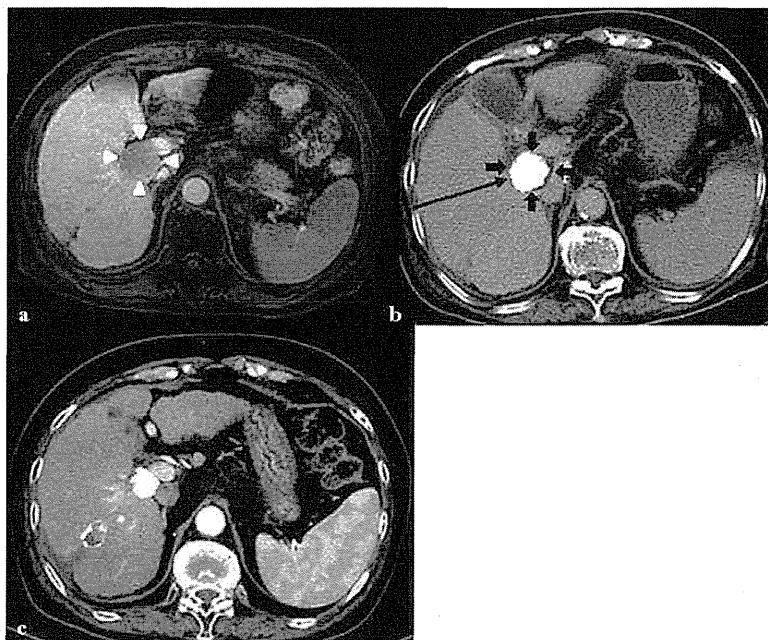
Case 4. (a) Dynamic magnetic resonance imaging (MRI) revealed hepatocellular carcinoma (HCC) 4.5 cm in diameter in the caudate process of the caudate lobe. The HCC lesion was adjacent to the portal vein trunk and inferior vena cava. (b) We performed trans-arterial chemoembolization (TACE) plus radiofrequency ablation (RFA). We were unable to detect the puncture route via the epigastric approach, because the lateral segment showed atrophy. Therefore, we used the right intercostal approach. The tumor was surrounded by hypoattenuating, non-enhancing areas on dynamic computed tomography (CT). (c) No local recurrence has been observed for 25.8 months after RFA.
